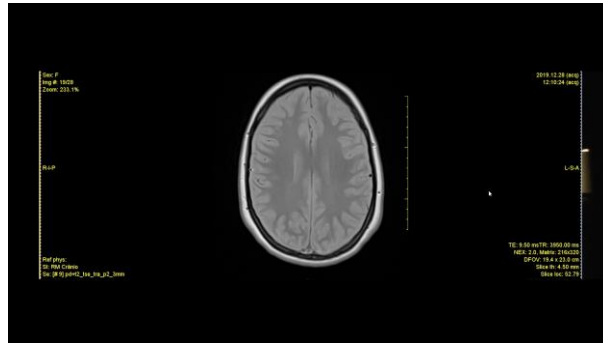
MRI still from “Land in Sight” (2021), by the author.
